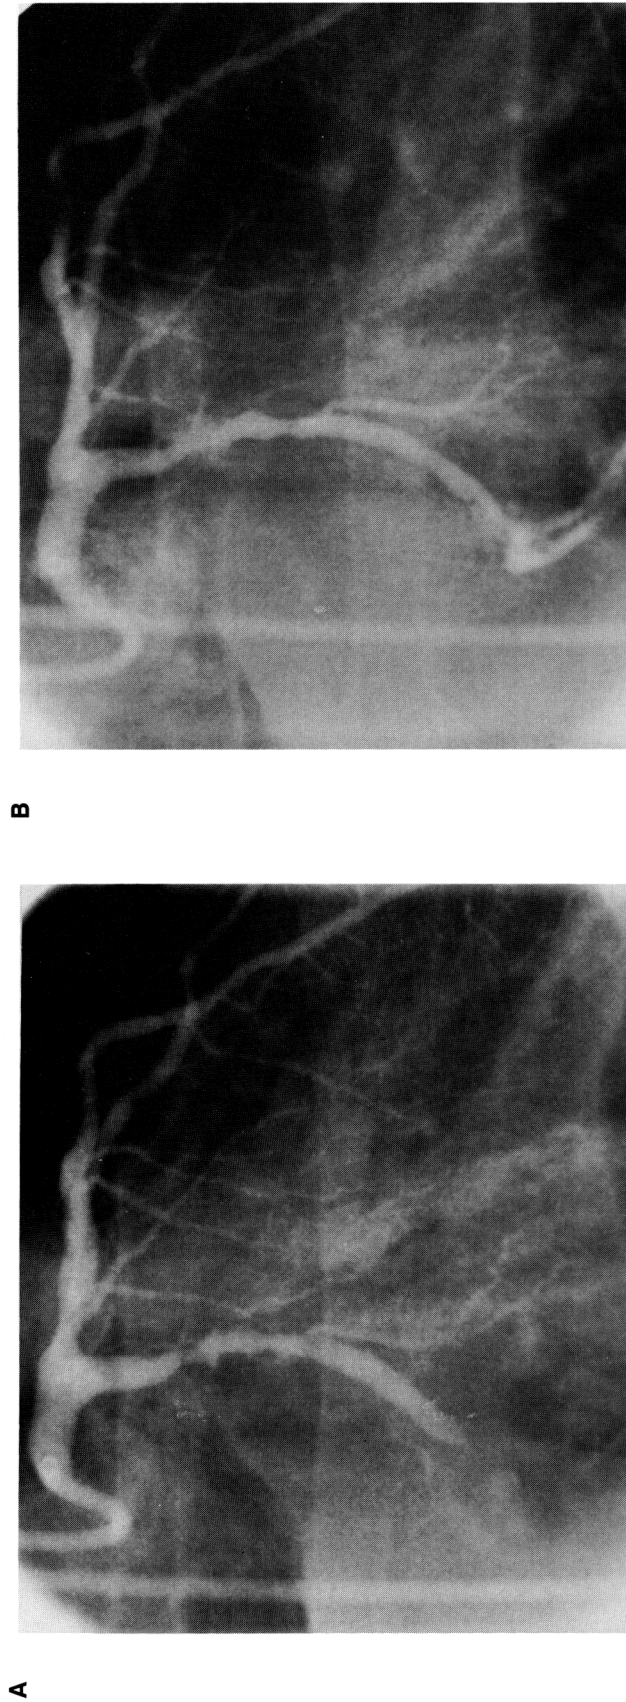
Panel A: Angiogram in the right anterior oblique projection demonstrates a 50% diameter narrowing of the proximal circumflex coronary artery and subtotal occlusion of the distal circumflex vessel. These obstructions were opened with a 3.0-mm angioplasty balloon. Panel B: Angiogram demonstrating a successful angiographic result. Panel C: Intravascular ultrasound image at the level of the proximal stenosis after balloon dilatation shows extensive residual atheroma with calcification that was not visualized on fluoroscopy. In addition, a dissection is present that is almost completely circumferential that could account for the apparent increase in width of the artery. Of note, a tear is not apparent in the atheroma at this level even though the atheroma is separated from the media.
